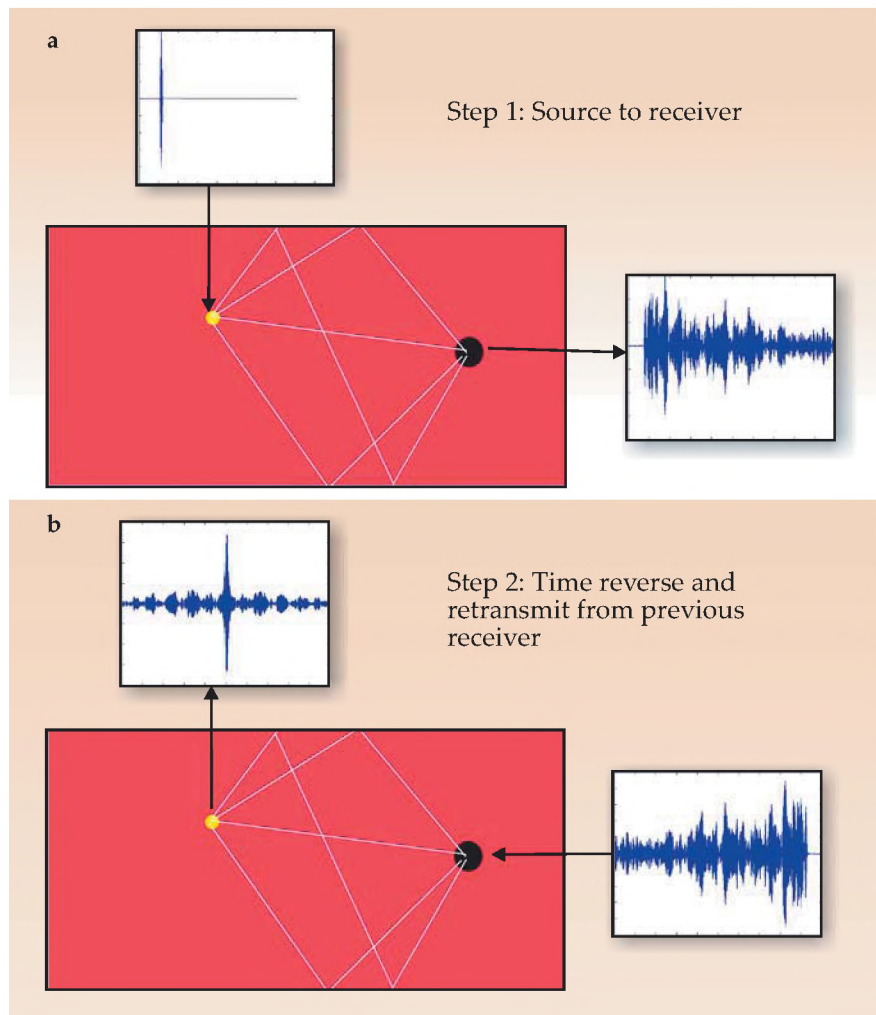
Time-reversal acoustics allows for impressive focusing of ultrasound pulses. (a) The yellow dot represents the region in which, ultimately, ultrasound is to be focused. But in the first step of TRA, that region acts as the source of a short burst. The signal received at the black dot is quite complicated. (b) Now the source is at the black dot and the initial waveform is the time reversal of the complicated signal received in panel a. The result is high temporal and spatial focusing at the yellow dot, the original source location. (Courtesy of Armen Sarvazyan, Artann Laboratories, West Trenton, New Jersey.)
